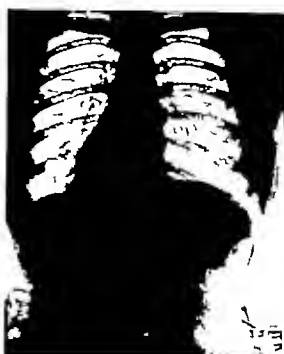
Roentgenogram of chest made on July 23, 1922.
